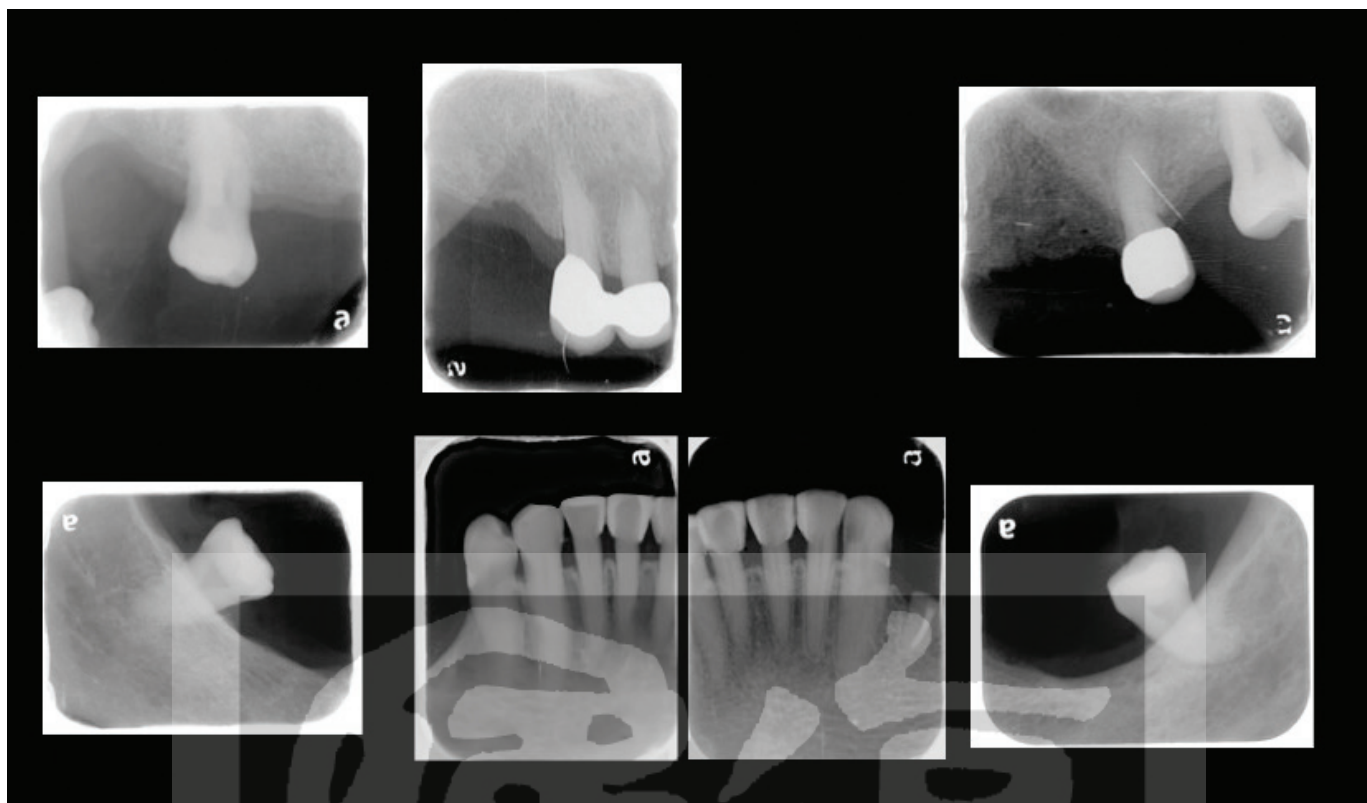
Postoperative periapical film.
